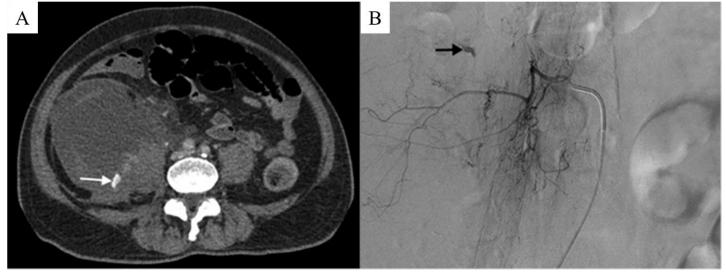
Images from a 75 year-old with retroperitoneal hematoma (patient 1). (A) Computed tomography angiography shows large right retroperitoneal hematoma with contrast extravasation (white arrow). (B) Digital subtraction angiographic image shows extravasation from branch of right L3 lumbar artery (black arrow).
